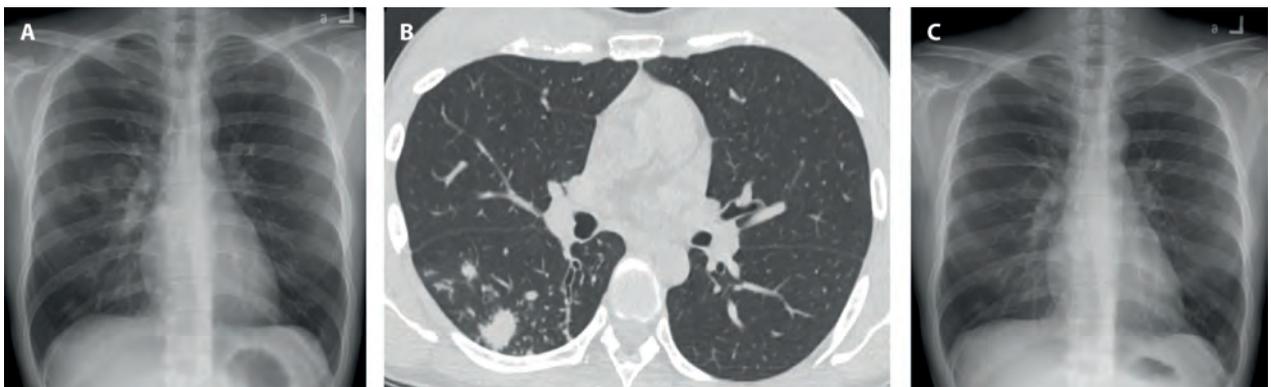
A-C) Pre- and post-treatment chest images of a 32-year-old female with culture-negative subclinical pulmonary TB. A) Pre-treatment chest radiograph shows patchy nodular opacities at the right middle lung zone. B) Axial CT image in lung window performed on the same date as A. reveals solid pulmonary nodules with adjacent centrilobular and tree-in-bud opacities in the superior segment of the right lower lobe as well as bronchial wall thickening and bronchiectasis. C) Post-treatment chest radiograph (10 months after A.) shows resolution of the abnormalities with minimal residual fibrosis at the right middle lung zone.
